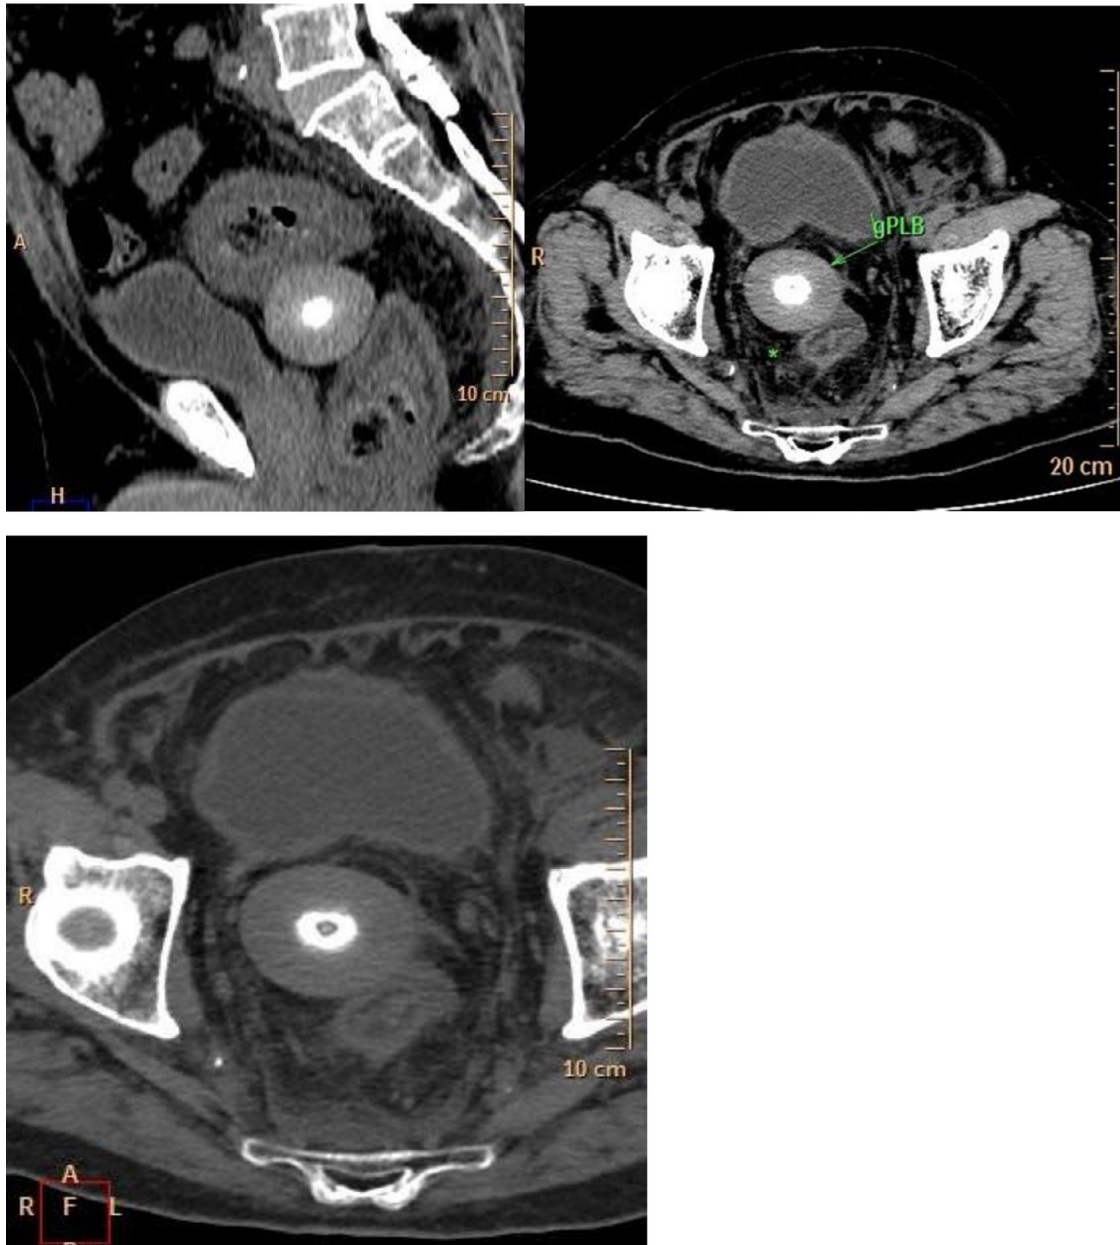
CT scan of abdomen (a showing Sagittal plane, b showing Axial plane and c showing Bone window of the lesion): revealing diffusely edematous, thickened wall of the rectum and sigmoid colon abutting a well-defined round to oval mass in the pelvis, measuring 6.2 cm x 5.8 cm, with a central high calcific density with surrounding thick mantle of soft tissue density. There was no demonstrable enhancement on post contrast study.
